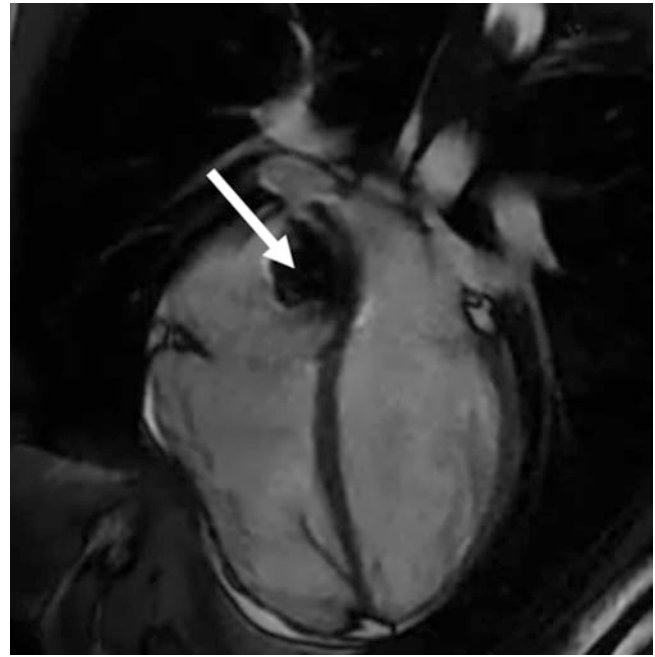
4-chamber cardiac MR image from a patient with an atrial septal repair implant (*arrow*) imaged at 1.5 T (Courtesy of Dr. Gianluca Pontone, Centro Cardiologico Monzino)
